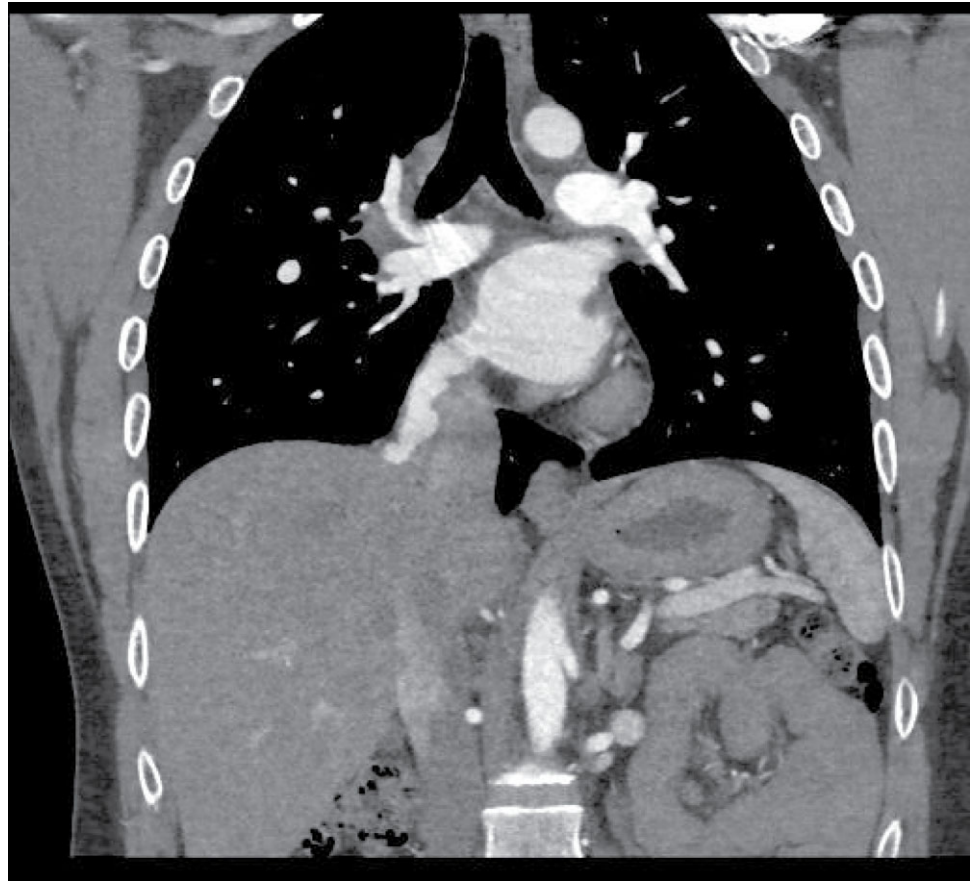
CT image of long tunnel redirecting partial anomalous pulmonary venous connection in the left atrium.
